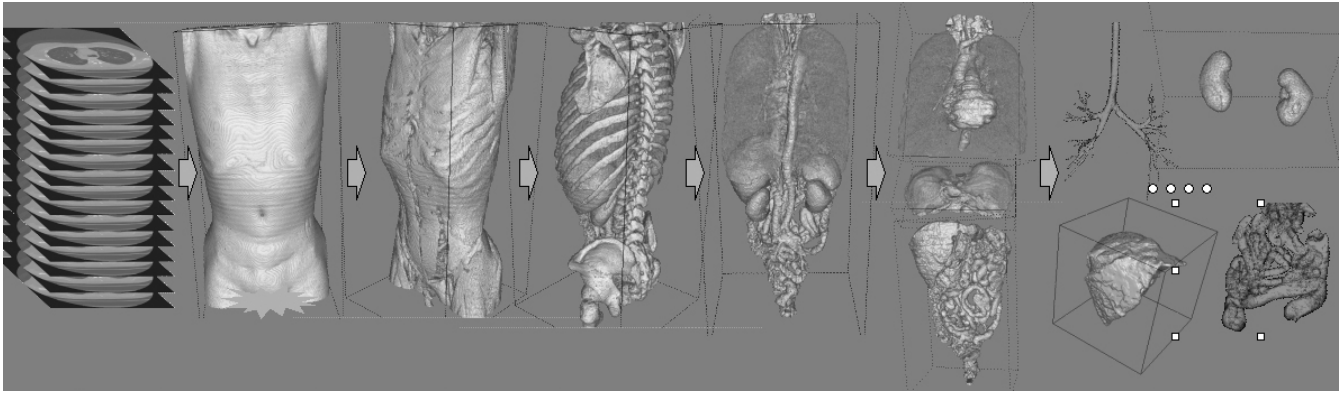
An example of anatomical structure recognition result from a torso CT case.
